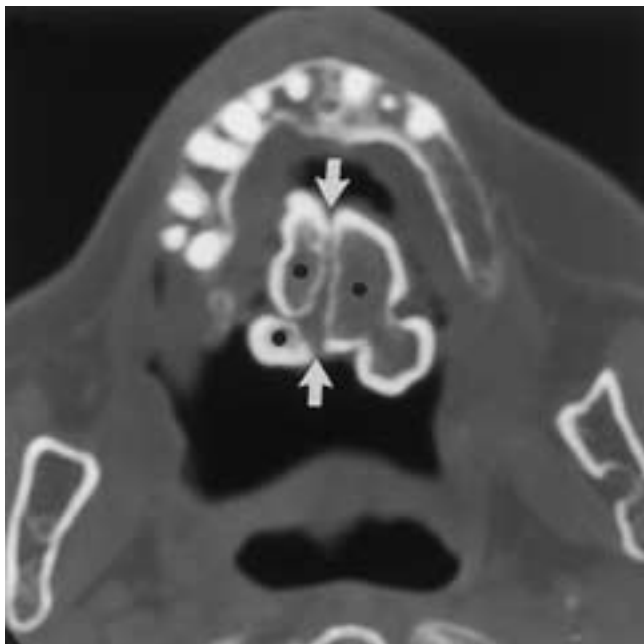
Torus palatinus. Axial CT scan obtained at a bone window setting demonstrates a very large torus palatinus projecting into the upper aspect of the oral cavity. The torus is multilobulated, with multiple areas of well-corticated cancellous bone (dots). A midline fissure is also present (arrows). (Courtesy of Dr. Deborah Reede.)
